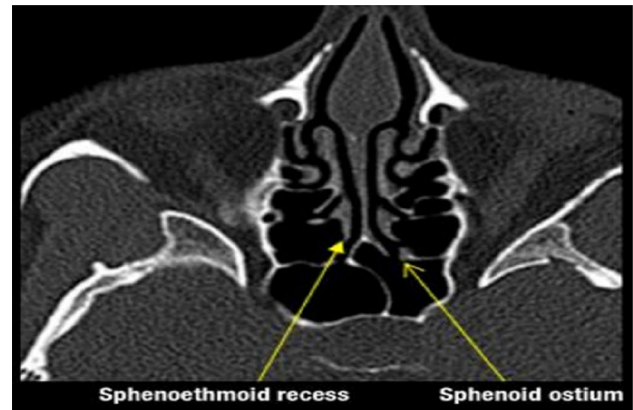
CT scan showing the natural sphenoid ostium and sphenoid recess
